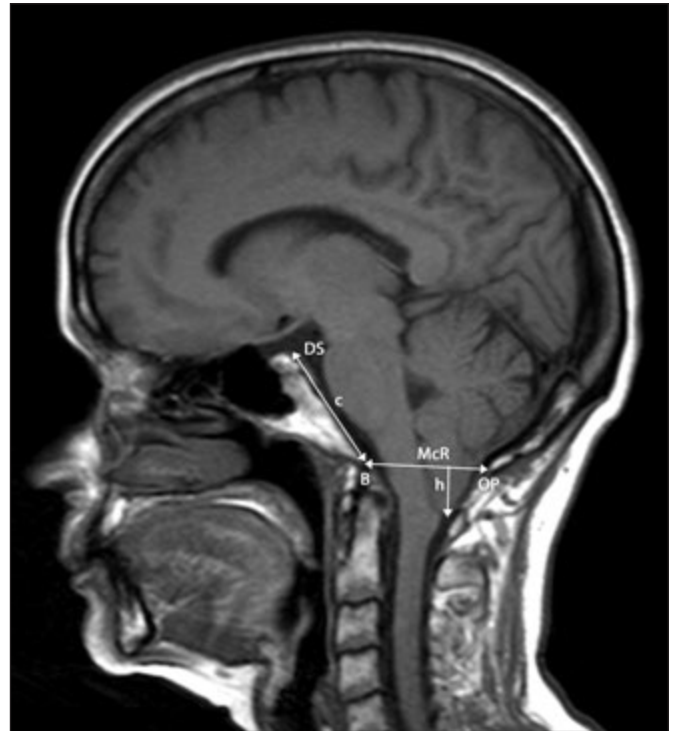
A T1-weighted sagittal MR image from a subject with Chiari I malformation, showing the midline structures of the posterior cranial fossa, the brainstem, and the cerebellum. McR = McRae's line; DS = top of the dorsum sellae; B = basion; OP = opisthion; c = length of clivus; h = length of tonsillar position relative to McRae's line.
